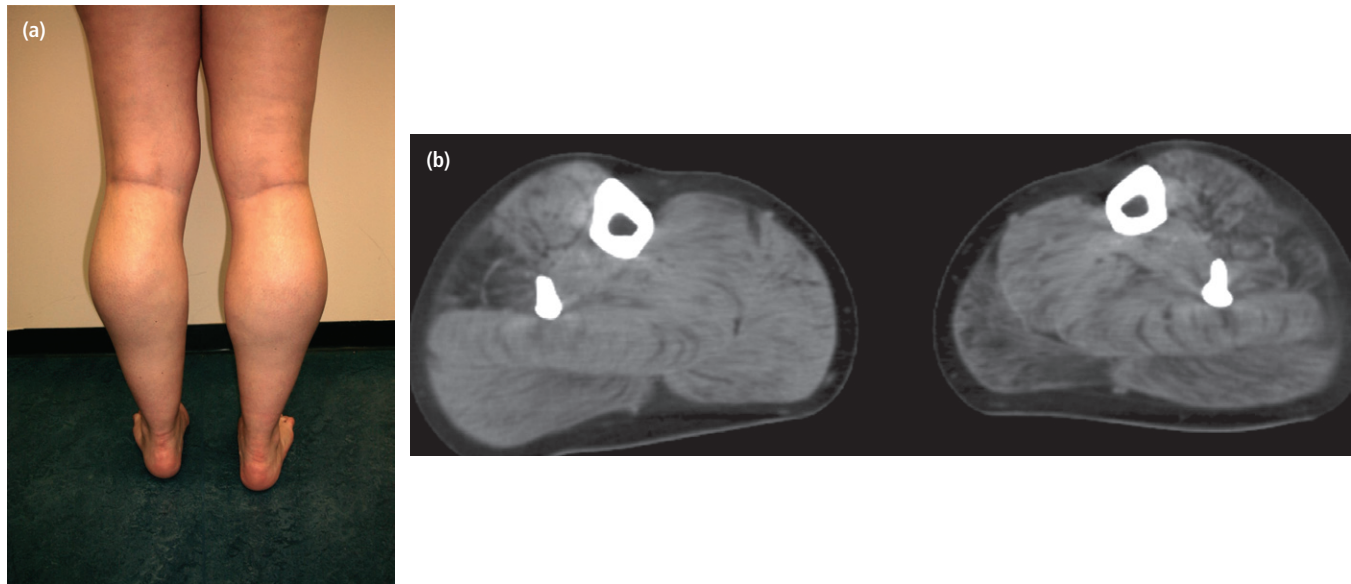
Duchenne muscular dystrophy carrier. (a) Hypertrophic calves. (b) CT shows fatty replacement of the calf muscles by fat, left more than right (pseudo-hypertrophy).
